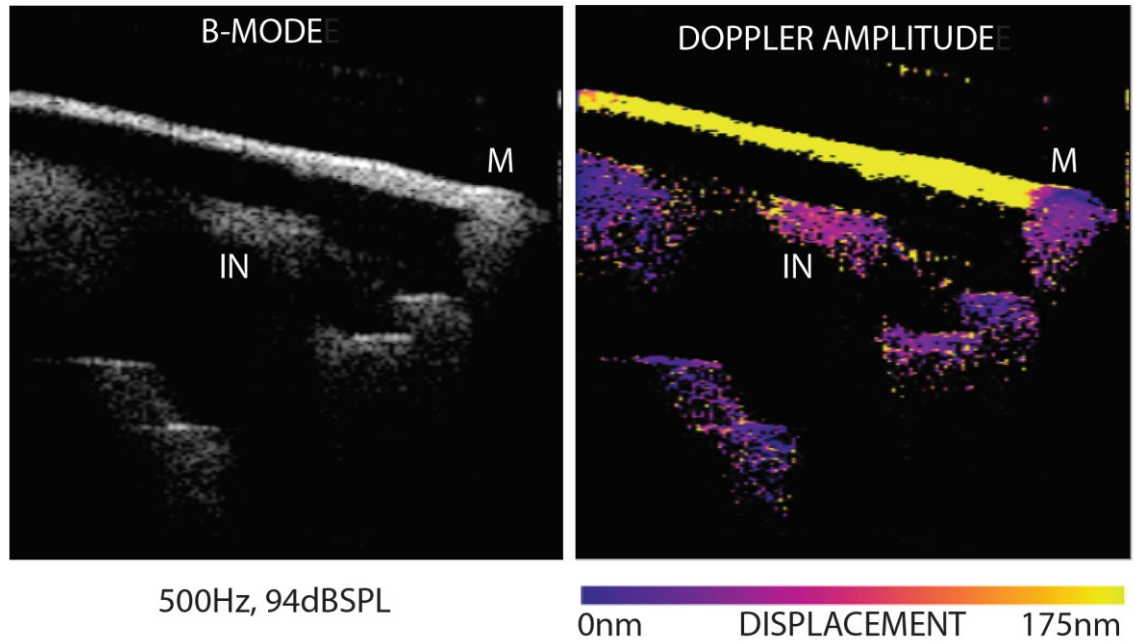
False colour overlay onto a B-mode (left) representing Doppler vibrational amplitude (right) [159].
